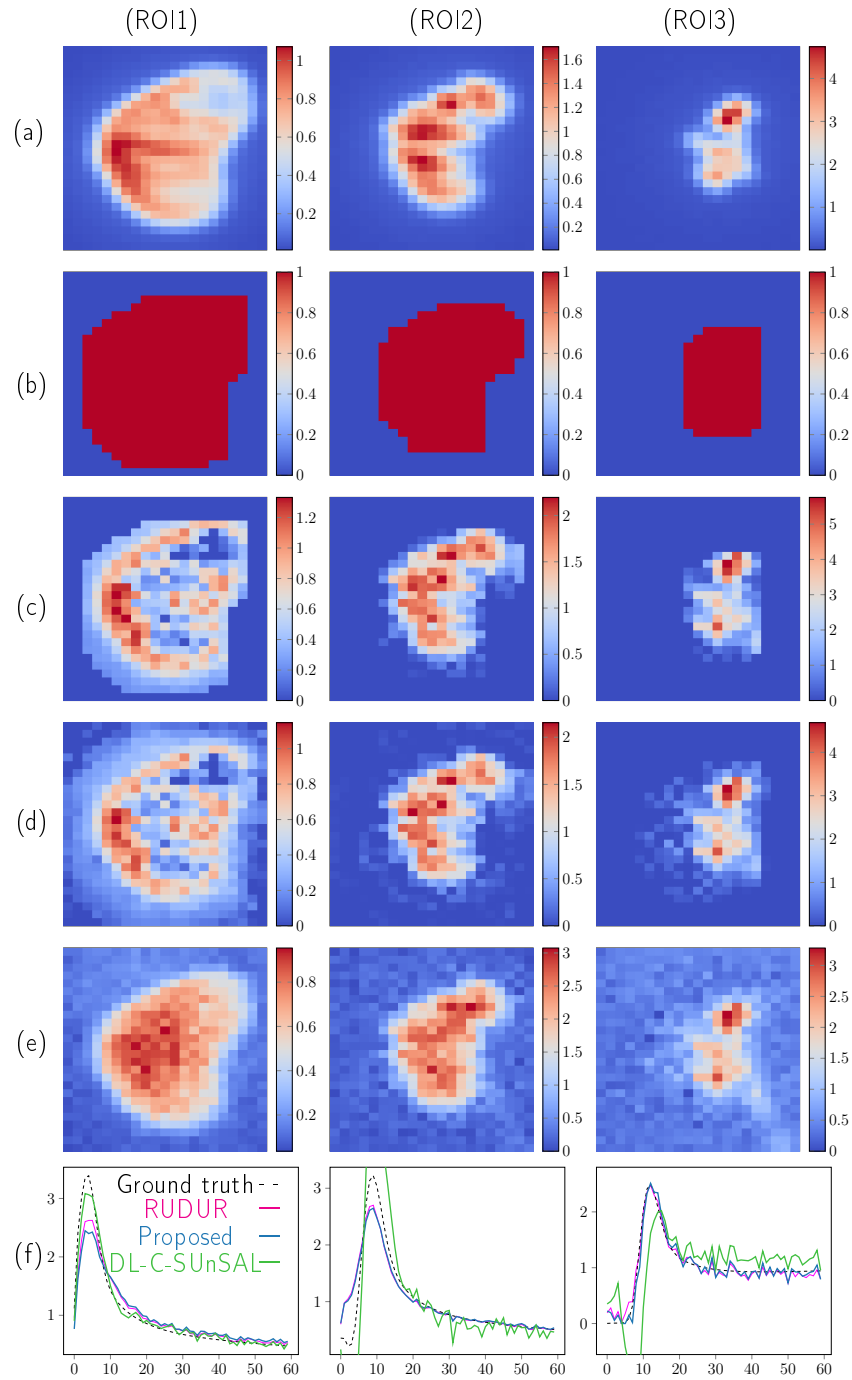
Données de scintigraphie. (a) vérité terrain pour les cartes spatiales, (b) regions initiales, (c) cartes spatiales estimées (d) cartes spatiales estimées par une méthode de l'état de l'art (RUDUR), (e) activités temporelles estimées par RUDUR et la méthode proposée.
